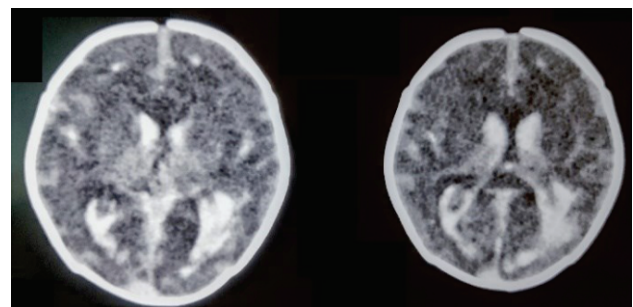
Cranial CT scan on 3rd day showing intraventricular, subarachnoid and intraparenchymal hemorrhage
